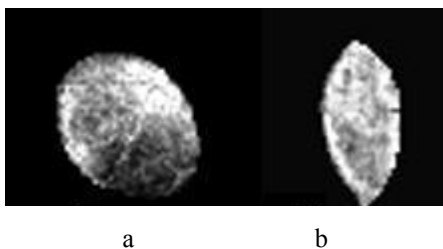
Outlined tumours from ultrasound B-scan images: a) – spindle cell uveal melanoma, b) – mixed cell uveal melanoma
